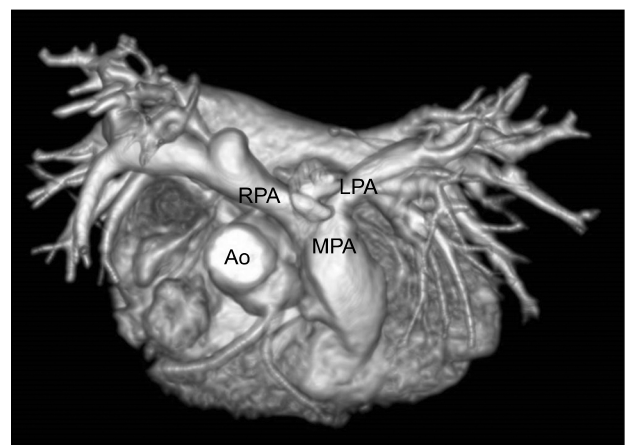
Enhanced postoperative computed tomography showing the well-reconstructed pulmonary arteries. Ao, aorta; MPA, main pulmonary artery; RPA, right pulmonary artery; LPA, left pulmonary artery.
